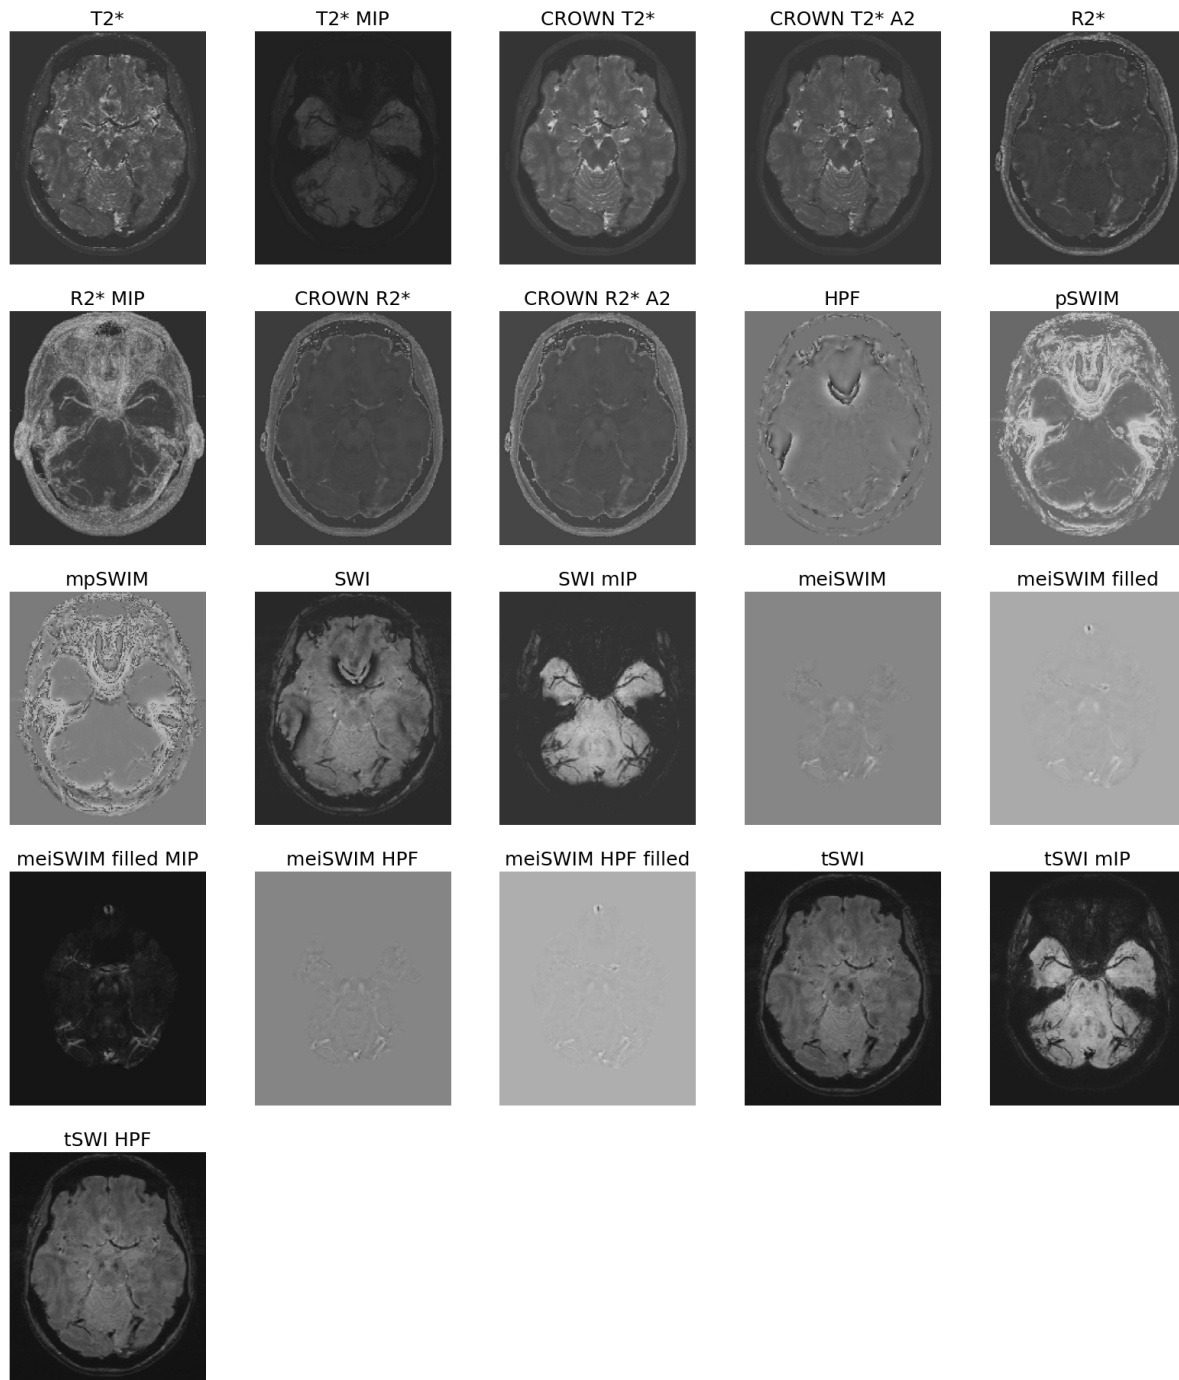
Iron-sensitive MRI images and maps for one of the TD patients. $T2^*$ = transverse relaxation time, MIP = maximum intensity projection, CROWN = constrained reconstruction of white noise, HPF = high-pass filtered phase, pSWIM = phase susceptibility-weighted imaging mapping, mpSWIM = multi-phase susceptibility-weighted imaging mapping, SWI = susceptibility-weighted image, mIP = minimum intensity projection, meiSWIM = multi-echo iterative susceptibility-weighted imaging mapping, tSWI = true susceptibility-weighted image, MRI = magnetic resonance imaging, TD = tremor-dominant.
